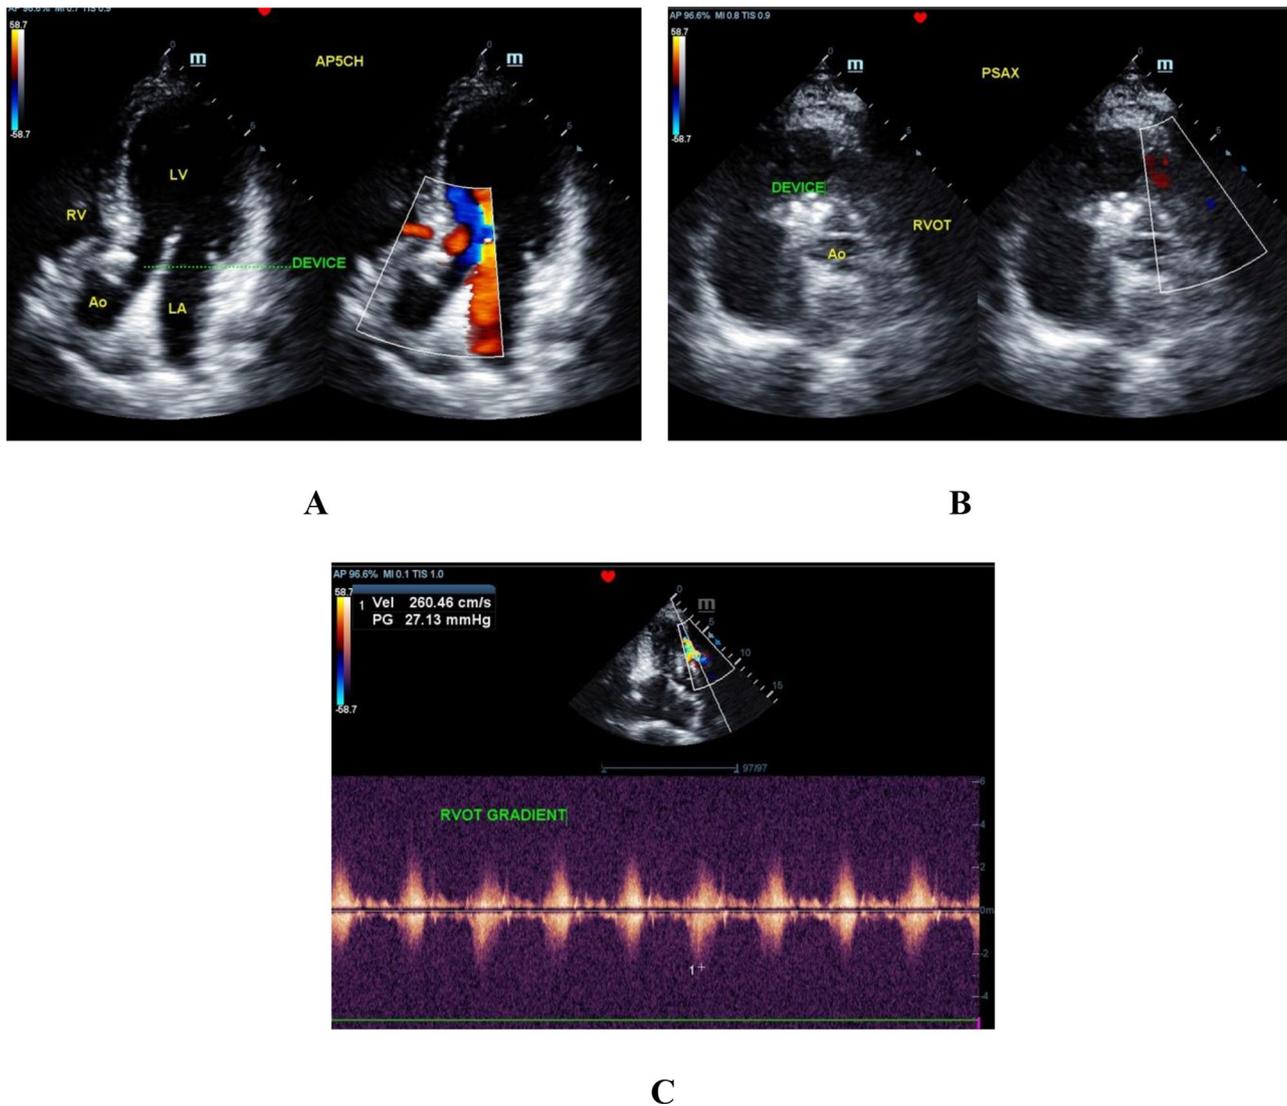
Follow up echocardiographic findings. A) Apical 5 chamber view showed device in situ with minimal flow through the device without any aortic regurgitation; B) Parasternal short axis view showed no pulmonic regurgitation; C) Continuous wave Doppler recording of the RVOT
